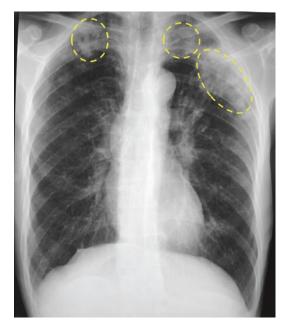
Chest radiography findings of pulmonary tuberculosis (TB) in a patient with brain tuberculoma (bilateral *upper* lobe TB lesions)
